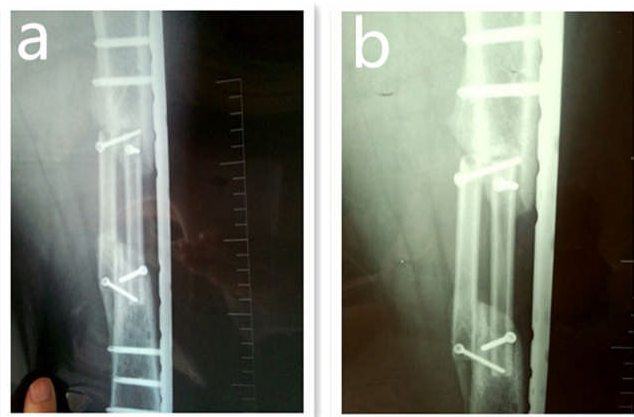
a. Radiograph: 6 months after the graft b. Radiograph: 12 months after the graft
